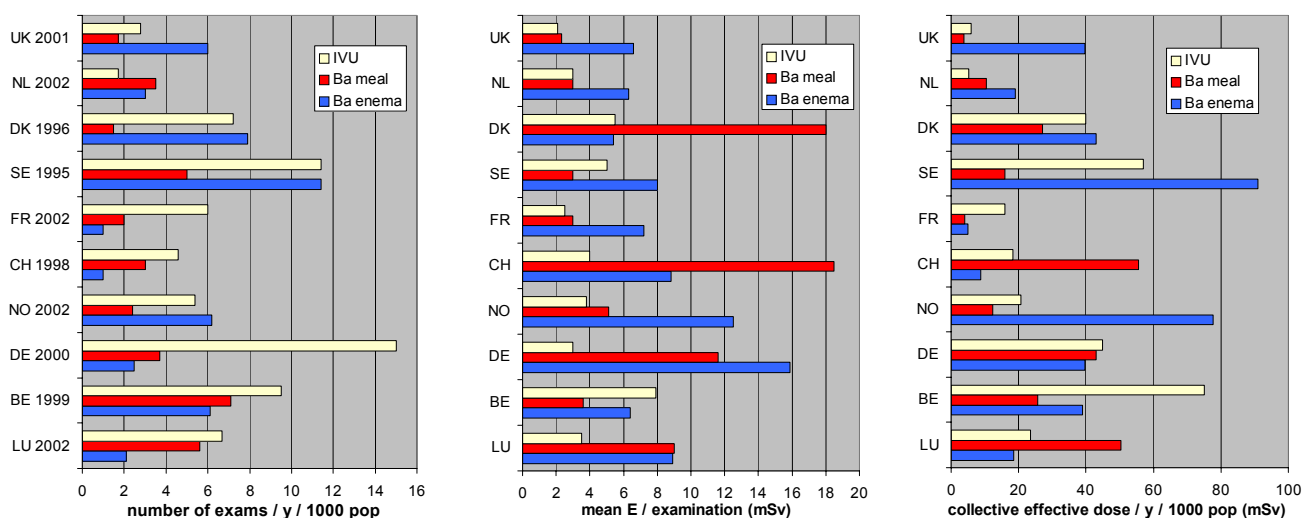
Frequency and dose data for three plain film radiographic exams in 10 countries
